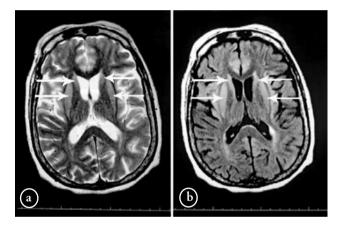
a) T2 MRI axial images demonstrating increased signal intensity in both putamine and caudate nuclei. b) Similar finding in the fluid attenuated inversion recovery sequence.
